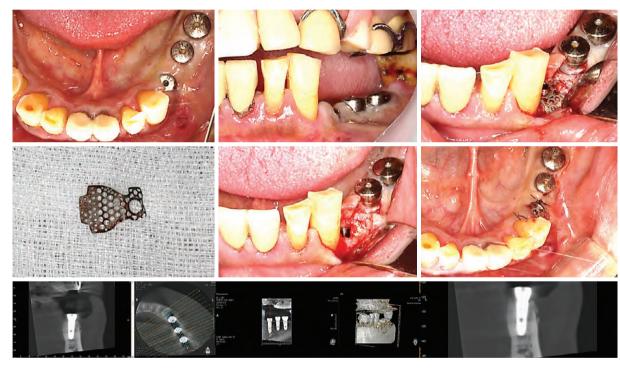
~21. 2nd-operative radiograph & Intra-operative view
